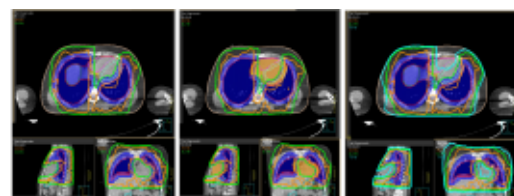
Cardiac substructures sparing Intensity Modulated Radiation Therapy (IMRT) plan showing 95% isodose line (orange), 90% (green), and 50% (blue) on CT images. Axial image, Sagittal and Coronal image showing biventricular sparing with IMRT.
